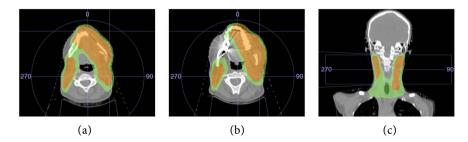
Axial (a) (b) and frontal (c) views of the planning CT scan. VMAT was delivered to the region of high risk to doses of 66 Gy and 56 Gy (95% isodose lines in orange and green respectively).
